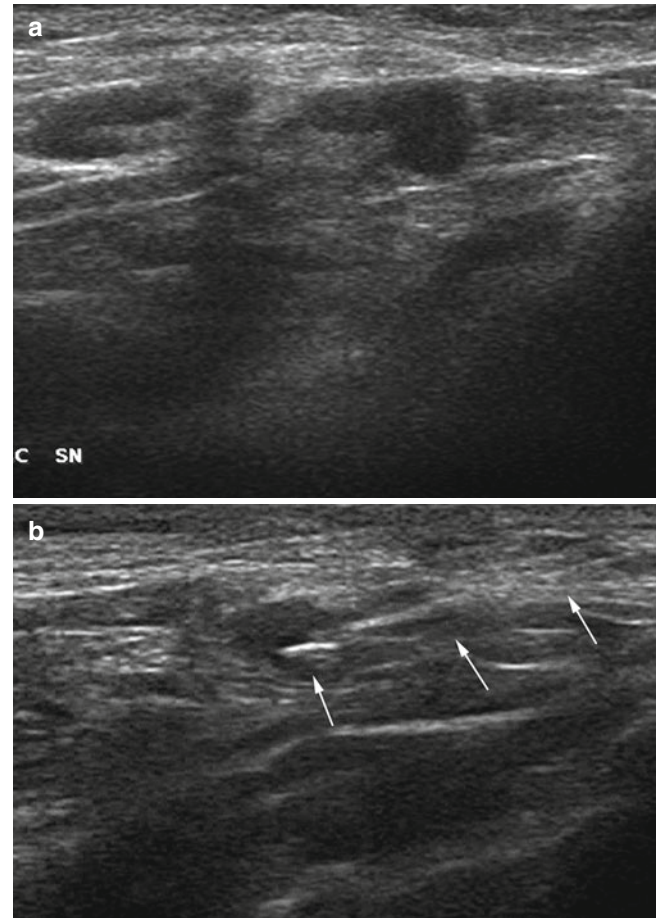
Fine-needle aspiration cytology (FNAC) of a metastatic axillary lymph node. A lymph node with a hypoechoic nodule is detected in a patient scheduled for sentinel lymph-node biopsy (a). Targeted, ultrasound-guided FNAC is subsequently performed. Note the needle (b, arrows) penetrating obliquely into the tumor deposit
